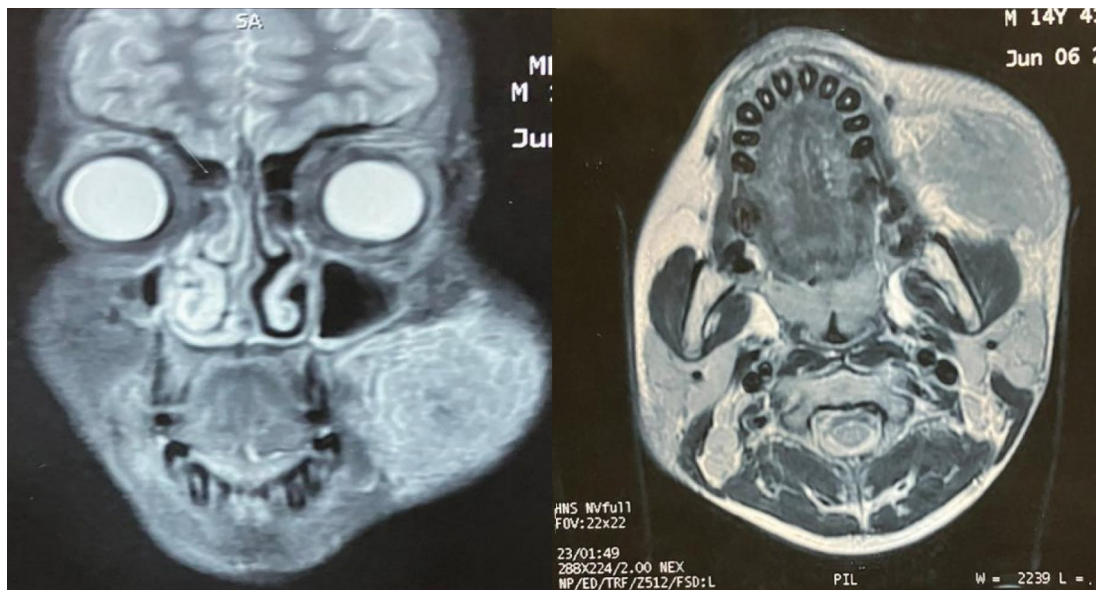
(Left) Coronal cut and (Right) Axial cut of MRI of face reveals a moderately well-defined SOL in the left buccal space. It is hypo-intense in T1 and T2WI. The left parotid duct is likely infiltrated and compressed by the SOL. The SOL is deep to the deep fascia of face, lying anterior and superficial to the left masseter. Left parotid gland is mildly atrophic.
